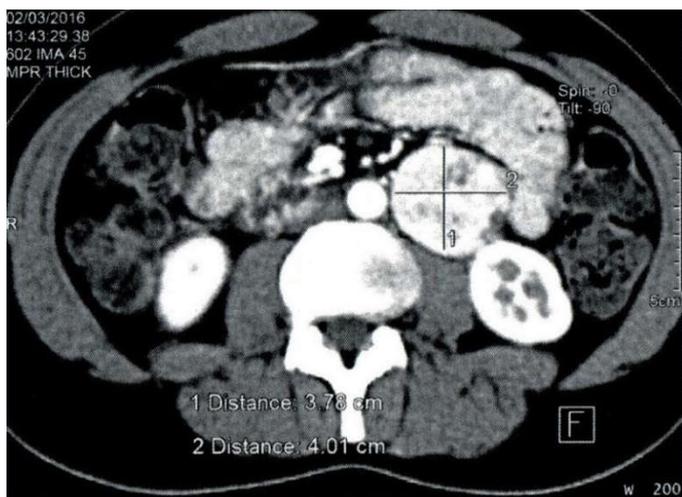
CT scan: retroperitoneal paraganglioma
